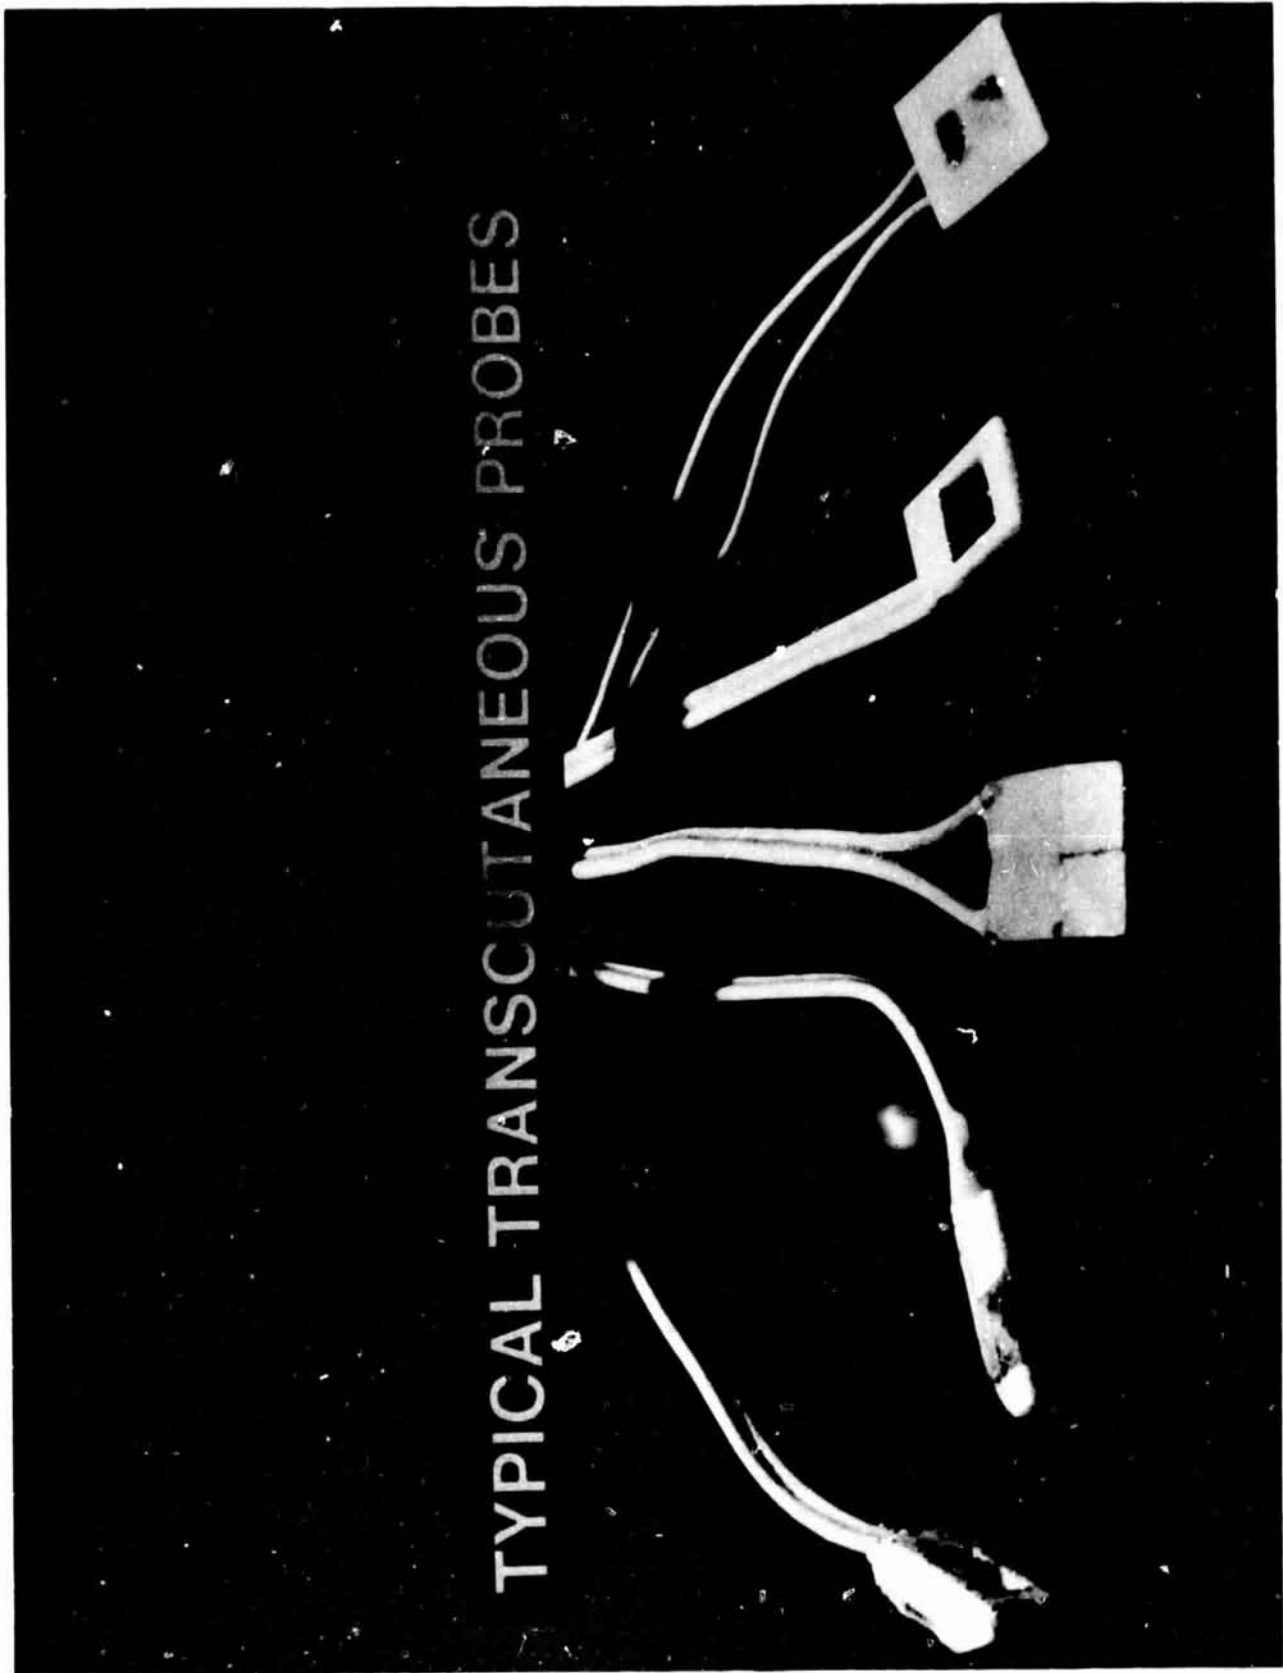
Typical ultrasonic Doppler blood flow probes for non-invasive use.
